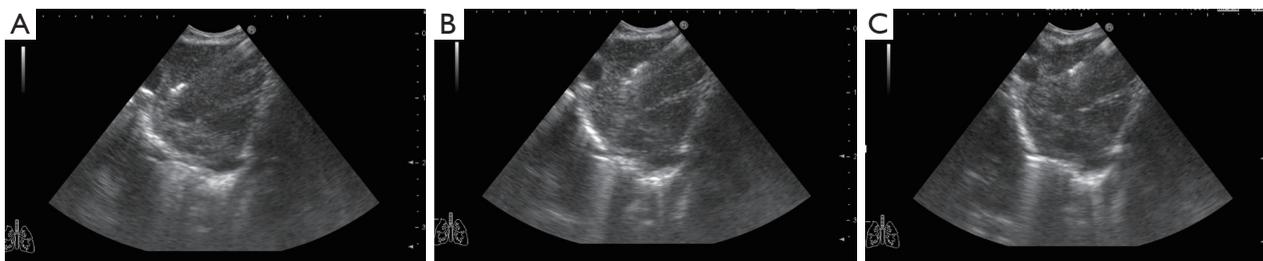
Ultrasound image of the cryoprobe. (A) Ultrasound image confirms the cryoprobe tip positioned distally within the lymph node. (B) Cryoprobe’s tip located in the lymph node’s medial area. (C) Cryoprobe’s tip positioned in the proximal zone of the lymph node.
